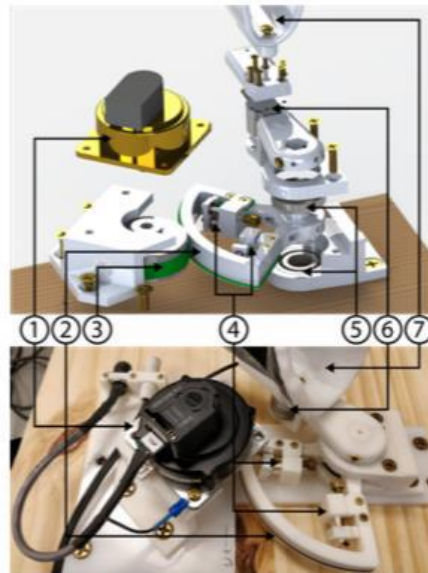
Exploded (above) and prototype (bottom) views of the MR- StretchWrist robot. (1) Ultrasonic motor, (2) Output pulley, (3) Input pulley, (4) Tensioning mechanisms, (5) Structural bearings, (6) Force/Torque Sensor, (7) hand support. Figure is adapted from [59].
